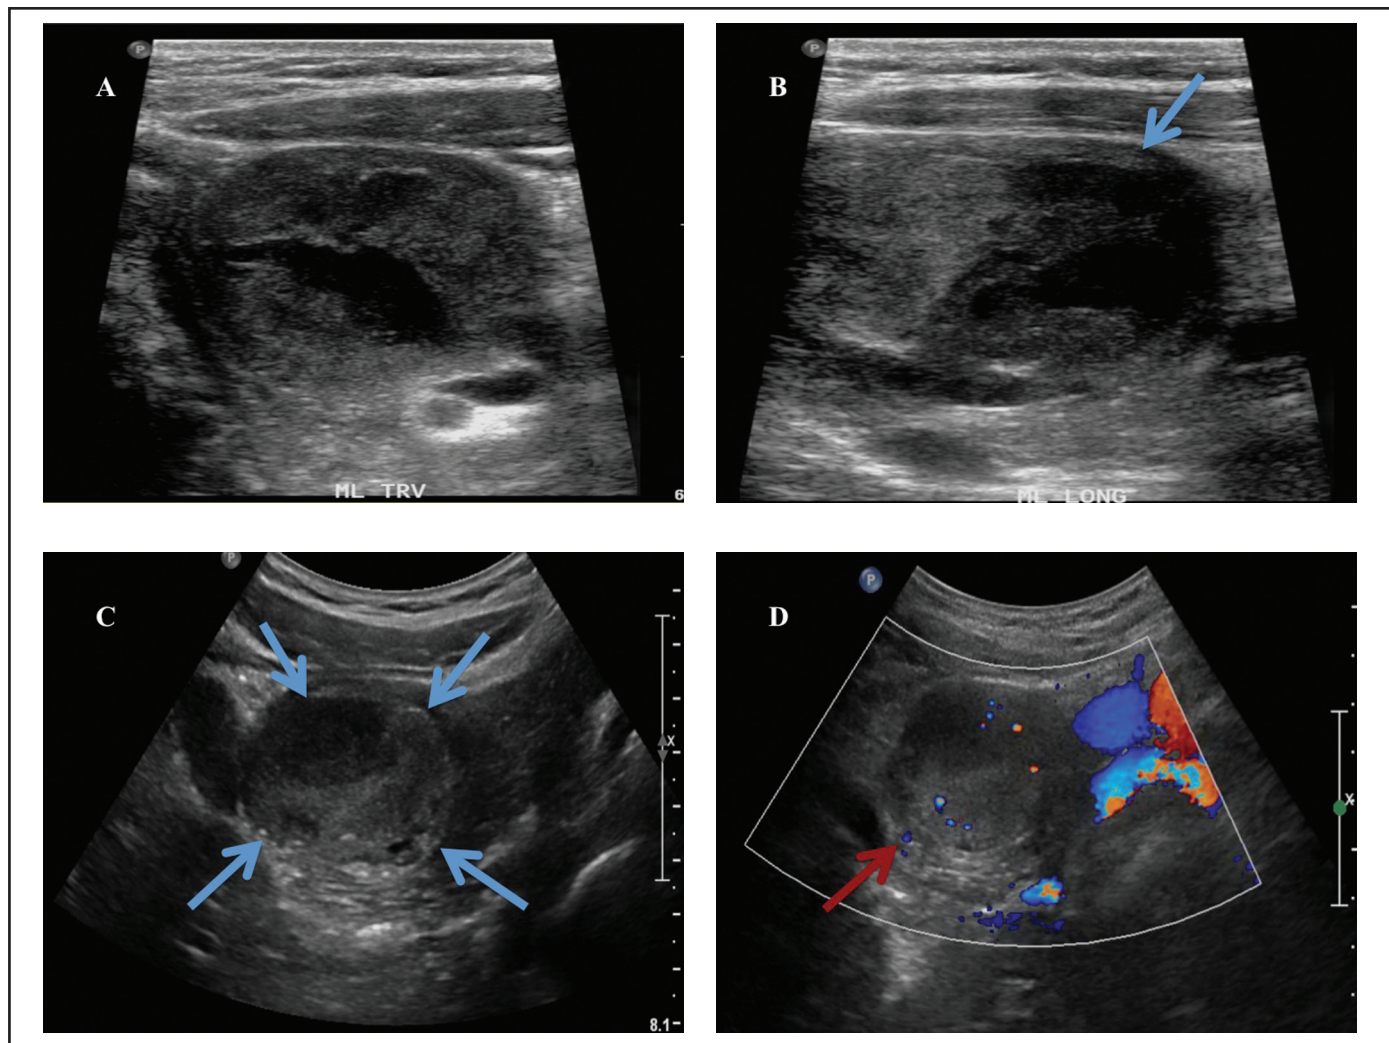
Week 5. (A) Transverse: Pancreatic head lesion. (B) Sagittal: Pancreatic head lesion with a homogeneous rim of pancreatic tissue (blue arrow). (C) Transverse: Pancreatic head lesion showing echogenic capsule (blue arrows) and hypoechoic rim of pancreatic tissue. (D) Colour Doppler: Pancreatic head lesion with twinkling artifact. Trace flow in the posterior lateral aspect of the lesion in the pancreatic tissue (red arrow).
